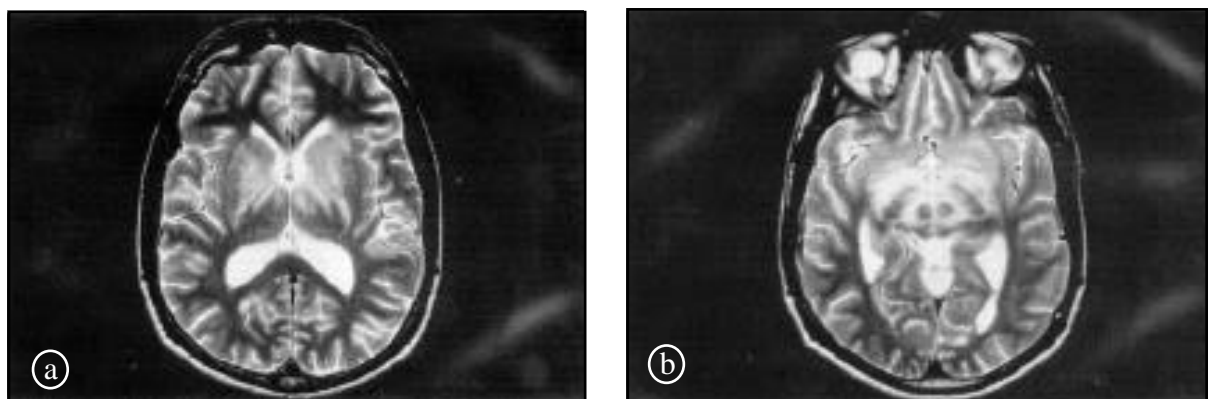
A 25-year-old male patient with neuro-Behcet disease. a) Brain MRI axial T₂ weighted image at the level of basal ganglia showing bilateral symmetrical homogenous high signal intensity in the caudate and lentiform nuclei. b) Axial T₂ weighted image at the level of crus cerebri showing homogenous high signal intensity sparing the red nucleus.
